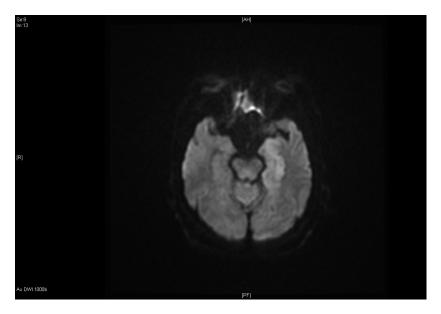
MRI scan after 36 hours Hypodensity involving medial part of the left temporal lobe and extending to the ipsilateral hippocampal and parahippocampal region
